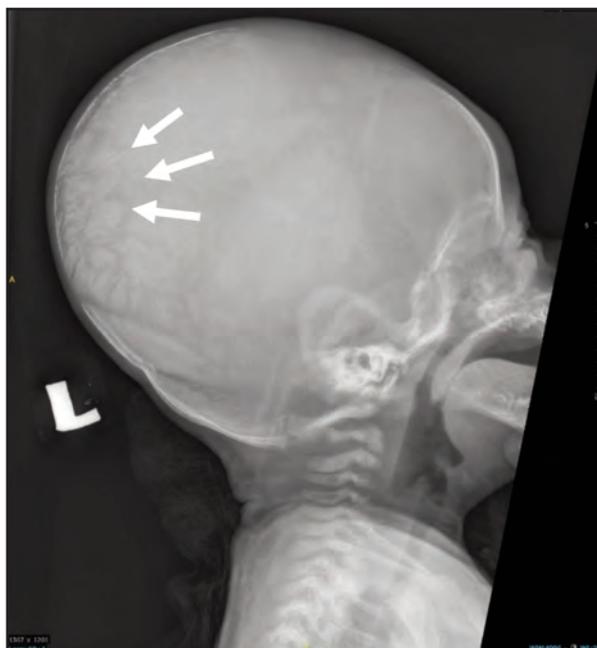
Skull radiograph showing presence of Wormian bones
